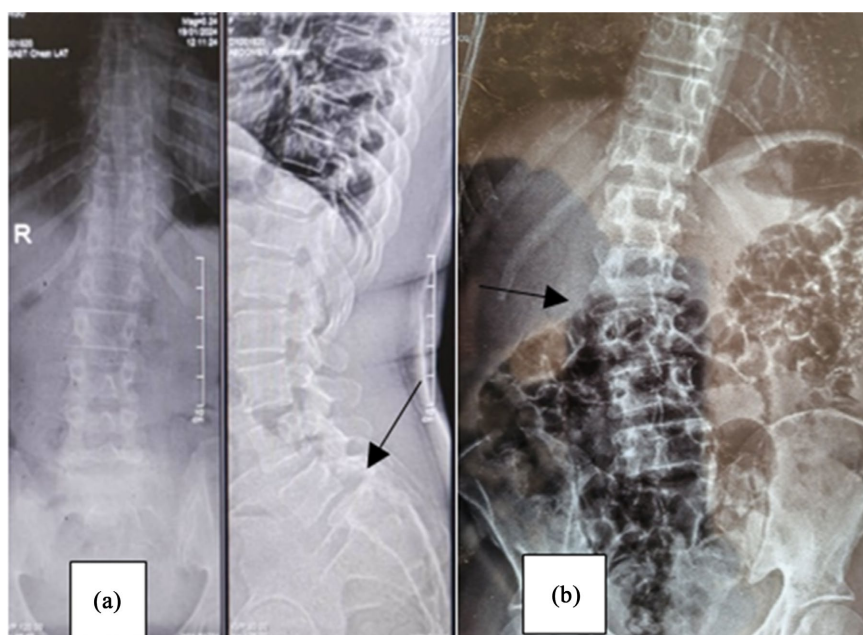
Radiographic images of women with chronic low back pain: (a) anterolisthesis at L5-S1 in a 38-year-old woman; (b) multilevel lumbar osteoarthritis (L2-L4) with right-convex scoliosis in a 41-year-old woman.
